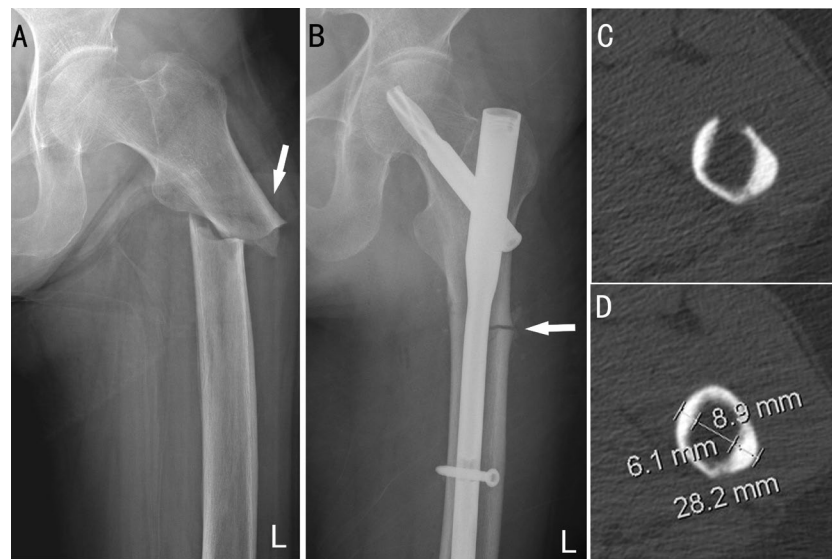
Preoperative radiographs (A) shows a transverse fracture of her left subtrochanteric femoral shaft (arrow); Postoperative radiographs (B) shows diffuse cortical thickening and beaking on the lateral cortex in the subtrochanteric region (arrow); The coronal cuts of CT scans (C,D) reveals that the size of the lateral cortical bone (8.9 mm) is thicker than the medial one (6.1 mm) obviously at the location where the fracture occurred.
